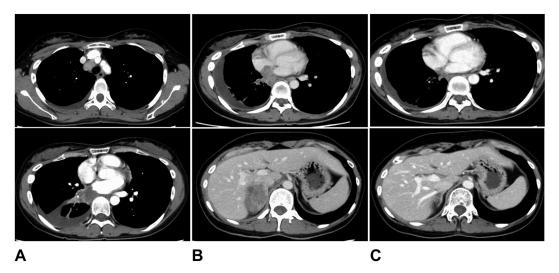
Timeline of tumor control (*A*) CT scan at diagnosis: The CT scan revealed a right lower lobe tumor, right pleural effusion, and mediastinal lymph node enlargement; (*B*) CT scan before combination therapy with the ABCP regimen: In addition to re-enlargement of the primary lesion, right adrenal metastasis was markedly increased; (*C*) CT scan after combination therapy with the ABCP regimen: The primary lesion and right adrenal metastases were shrinking. ABCP, atezolizumab, bevacizumab, carboplatin, and paclitaxel; CT, computed tomography.
